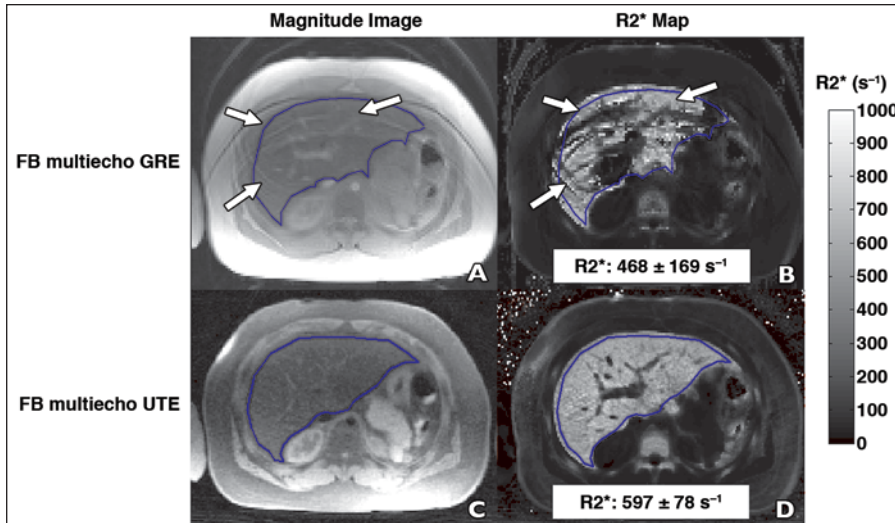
10-year-old girl with sickle cell disease and high iron overload who was sedated. A–D, First-echo magnitude MR images of liver (A and C) and respective R2* (B and D) maps acquired by free-breathing (FB) multiecho gradient-recalled echo (GRE) imaging (A and B) and FB multiecho ultrashort TE (UTE) imaging (C and D) show comparison of FB sequences. Mean R2* value (\pm SD) was calculated for whole-liver ROI (blue outline, A–D) after exclusion of blood vessels by histogram analysis. Motion artifacts (arrows) are visible on magnitude image (A) and R2* map (B) acquired using FB multiecho GRE imaging. Mean R2* value obtained by FB multiecho GRE imaging was lower by 22% and SD was twofold higher, compared with FB multiecho UTE imaging. In contrast, FB multiecho UTE (C and D) images were cleaner than FB multiecho GRE images (A and B), with only minor residual streaking artifacts from radial sampling. FB multiecho UTE R2* map (D) shows better representation of portal vein than does FB multiecho GRE R2* map (B). Applying BH multiecho GRE R2* hepatic iron content (HIC) calibration equation [36] to calculated R2* values results in HIC of 17.9 mg Fe/g of dry liver weight for FB multiecho UTE imaging and HIC of 13.9 mg Fe/g of dry liver weight for FB multiecho GRE imaging, which may be indicative of HIC underestimation.
